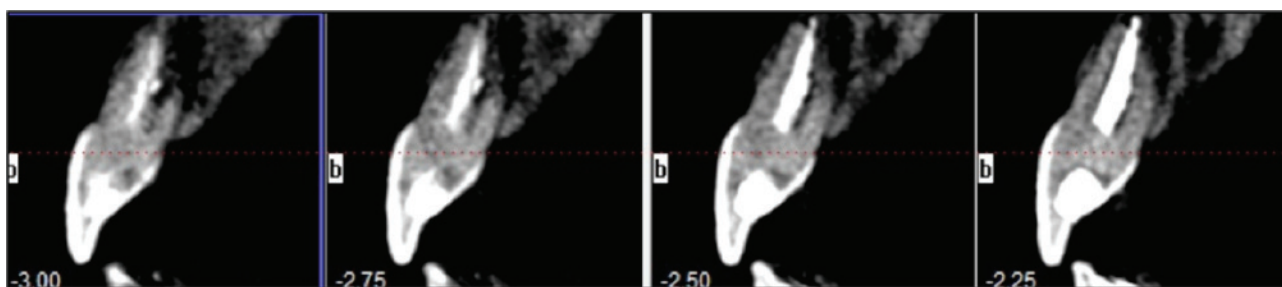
Cone beam computed tomography analysis.
